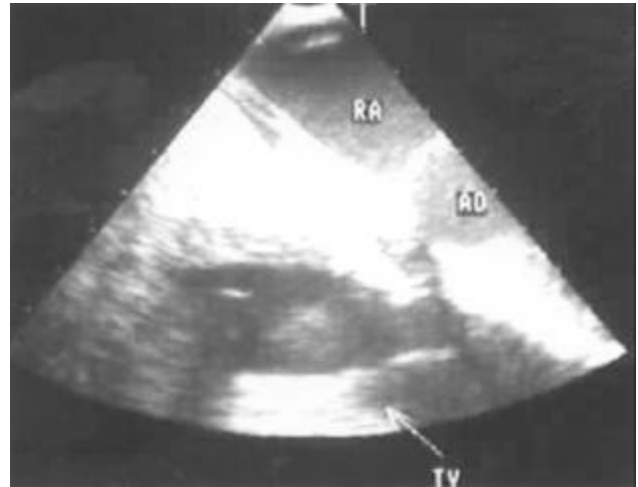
2D-doppler echocardiography (TEE) after atrial tumor resection.
